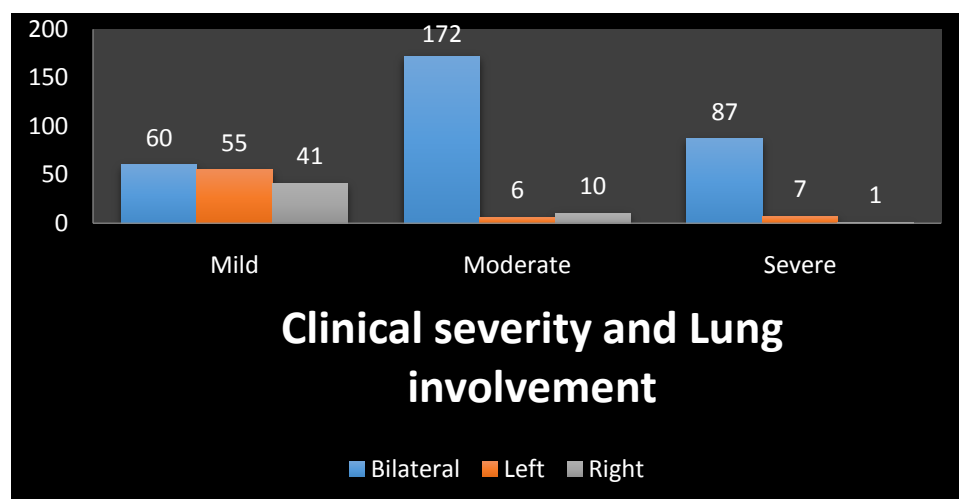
ASSOCIATION OF CLINICAL SEVERITY AND LUNG INVOLVEMENT IN XRAY
